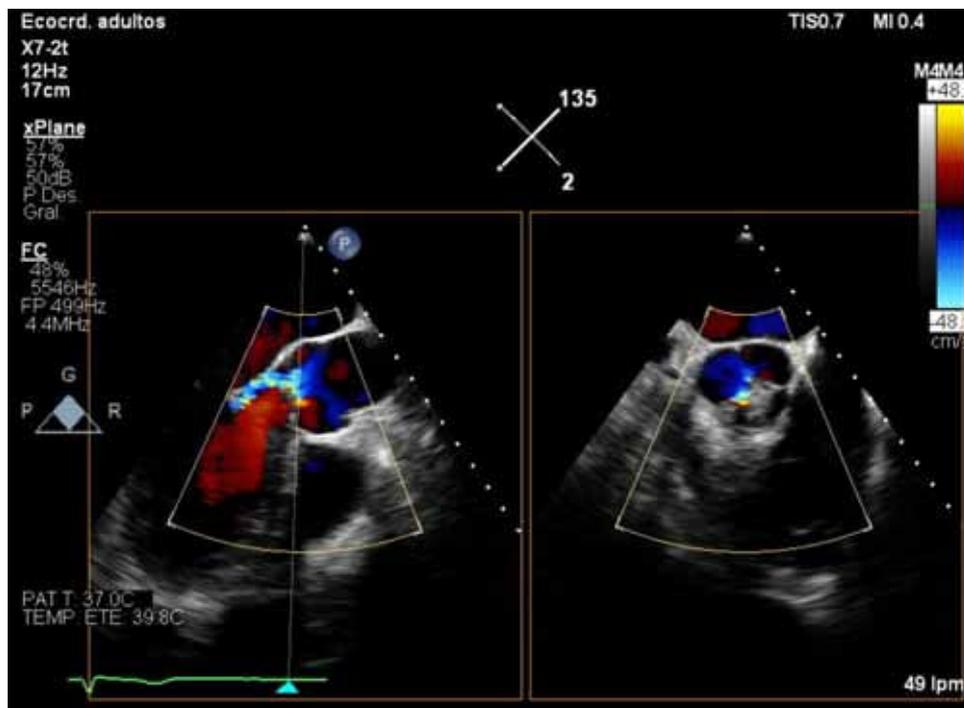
Color Doppler transesophageal echocardiography of the aortic valve with orthogonal planes to the long axis (135°) and short axis (45°).
